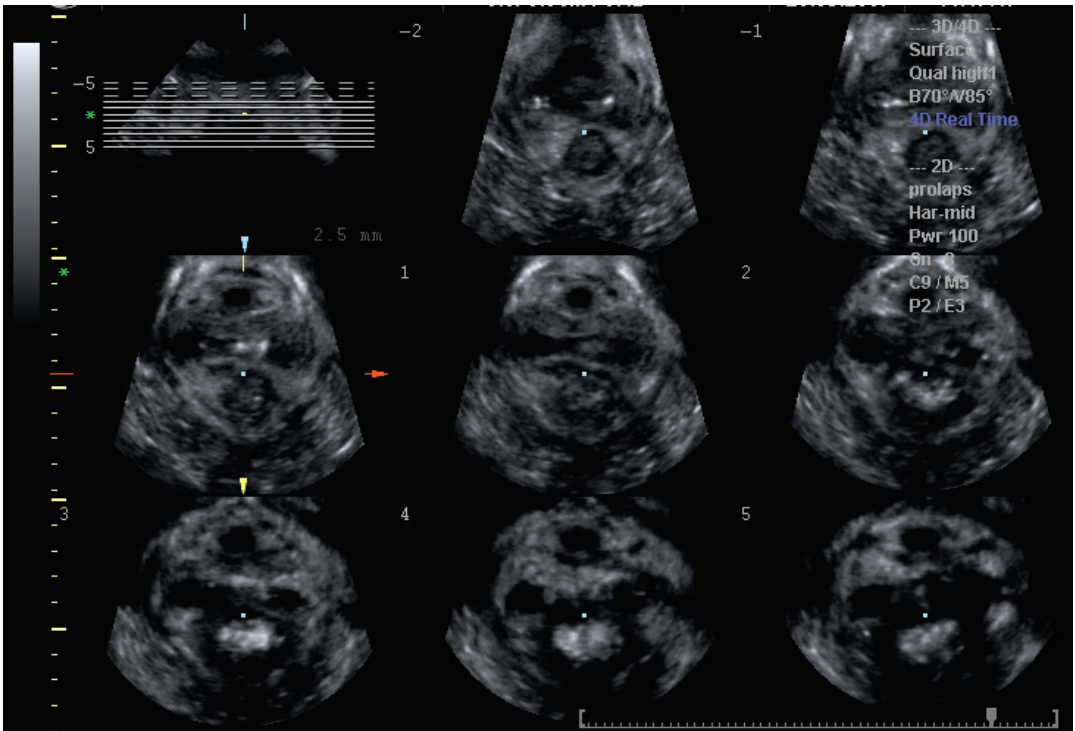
Tomographic ultrasound imaging in oblique axial plane. Bilateral avulsion of the levator ani muscle from the symphysis pubis.
